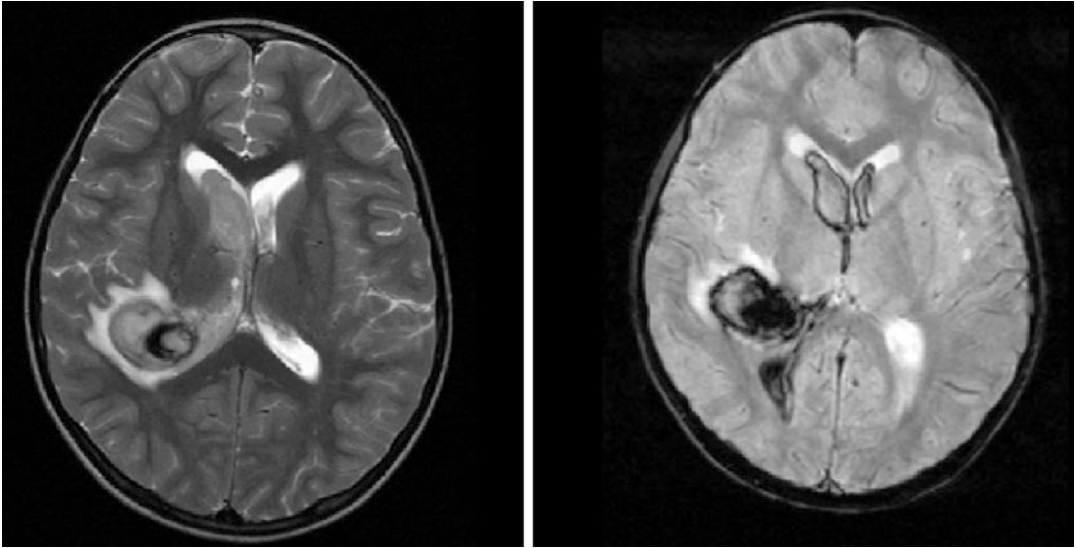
Acute intracerebral haemorrhage. Right: Axial T2 MRI showing intermediate signal haematoma with extension into the right lateral ventricle. Left: Axial T2* Gradient Echo showing low signal hemosiderin within the haematoma
